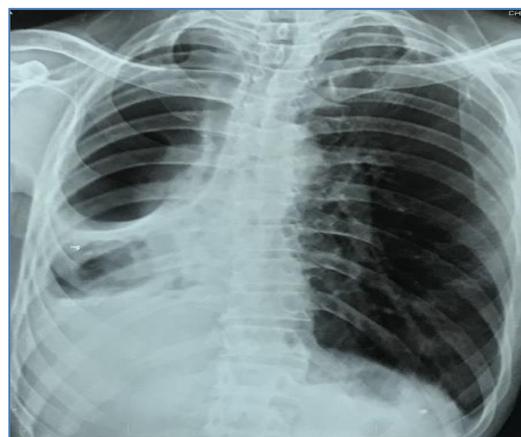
Chest x-ray PA showing large fibrocavity in right lung with upper and lower mediastinal shift to right side
